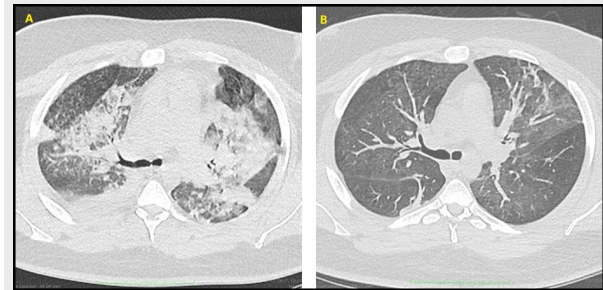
(A) CT scan at day 6 showing diffuse condensations and “tree-in-bud” micronodules. (B): CT scan after corticosteroids boluses showing marked improvement with regression of lung damage.
